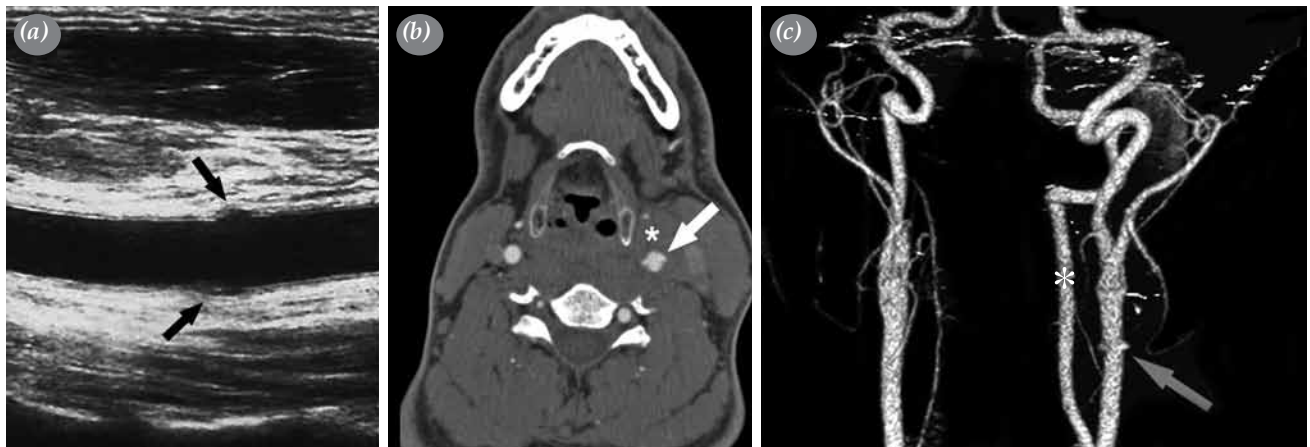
(a) Coronal B-mode ultrasound image obtained from the level of distal common carotid artery. Focal medial and lateral intimal defects of the common carotid artery seen at the injury site (black arrows). (b) Axial contrast enhanced computed tomography image and (c) three-dimensional volume rendered image of the same level. Complete penetration of common carotid artery characterized by contrast enhancement (white arrow, grey arrow). Note the obliterated perivascular fat planes due to hemorrhage (white asterisk in B). The patient had hypoplastic right vertebral artery and left dominant vertebral artery flow (white asterisk in C).
